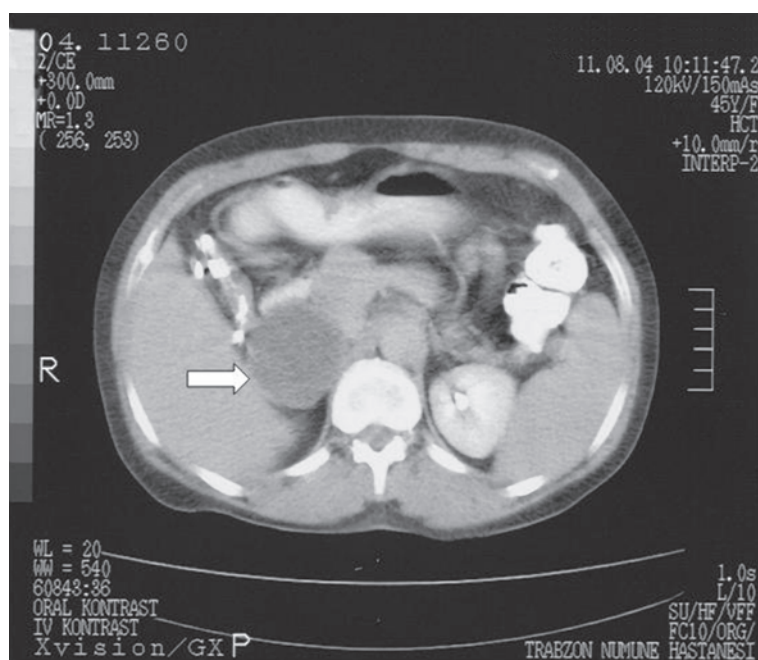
Contrast-enhanced axial CT scan shows a well-defined hypodense cystic mass at the right adrenal gland (arrow).
